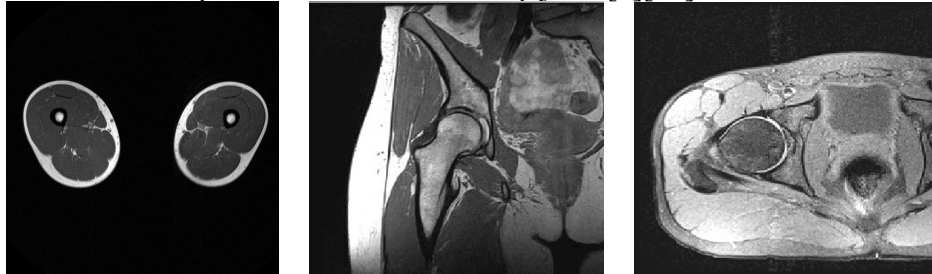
Examples of magnetic resonance images
